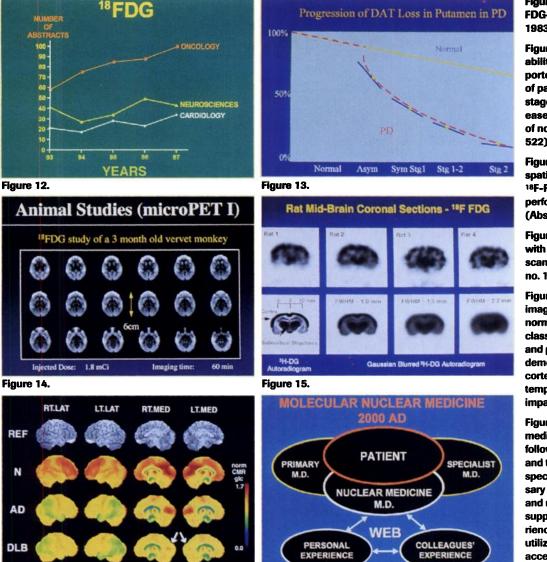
Relative growth of FDG-PET presentations since 1983.
